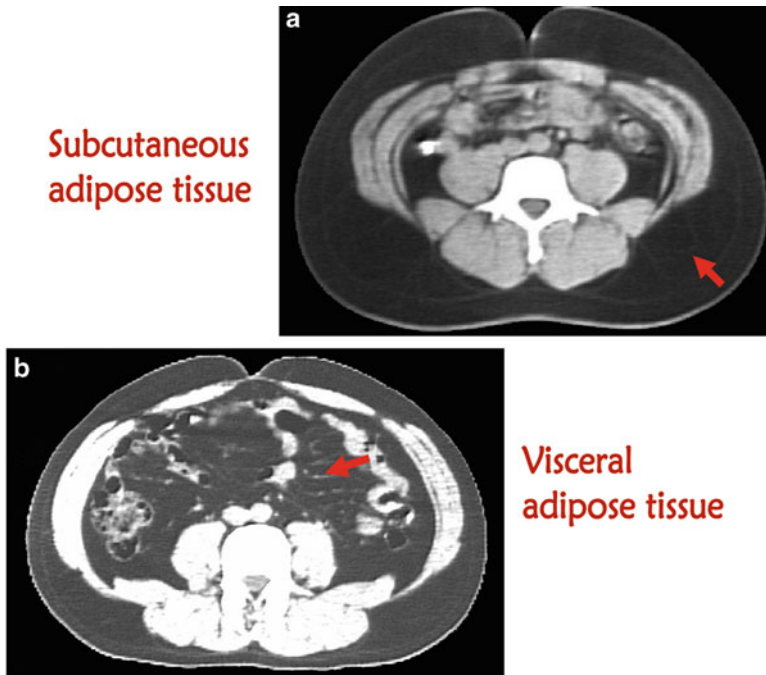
A representation of two computed tomography slides. Subcutaneous fat-type with prominence of subcutaneous AT (a). Visceral fat-type: excess fat in the visceral compartment (b)
